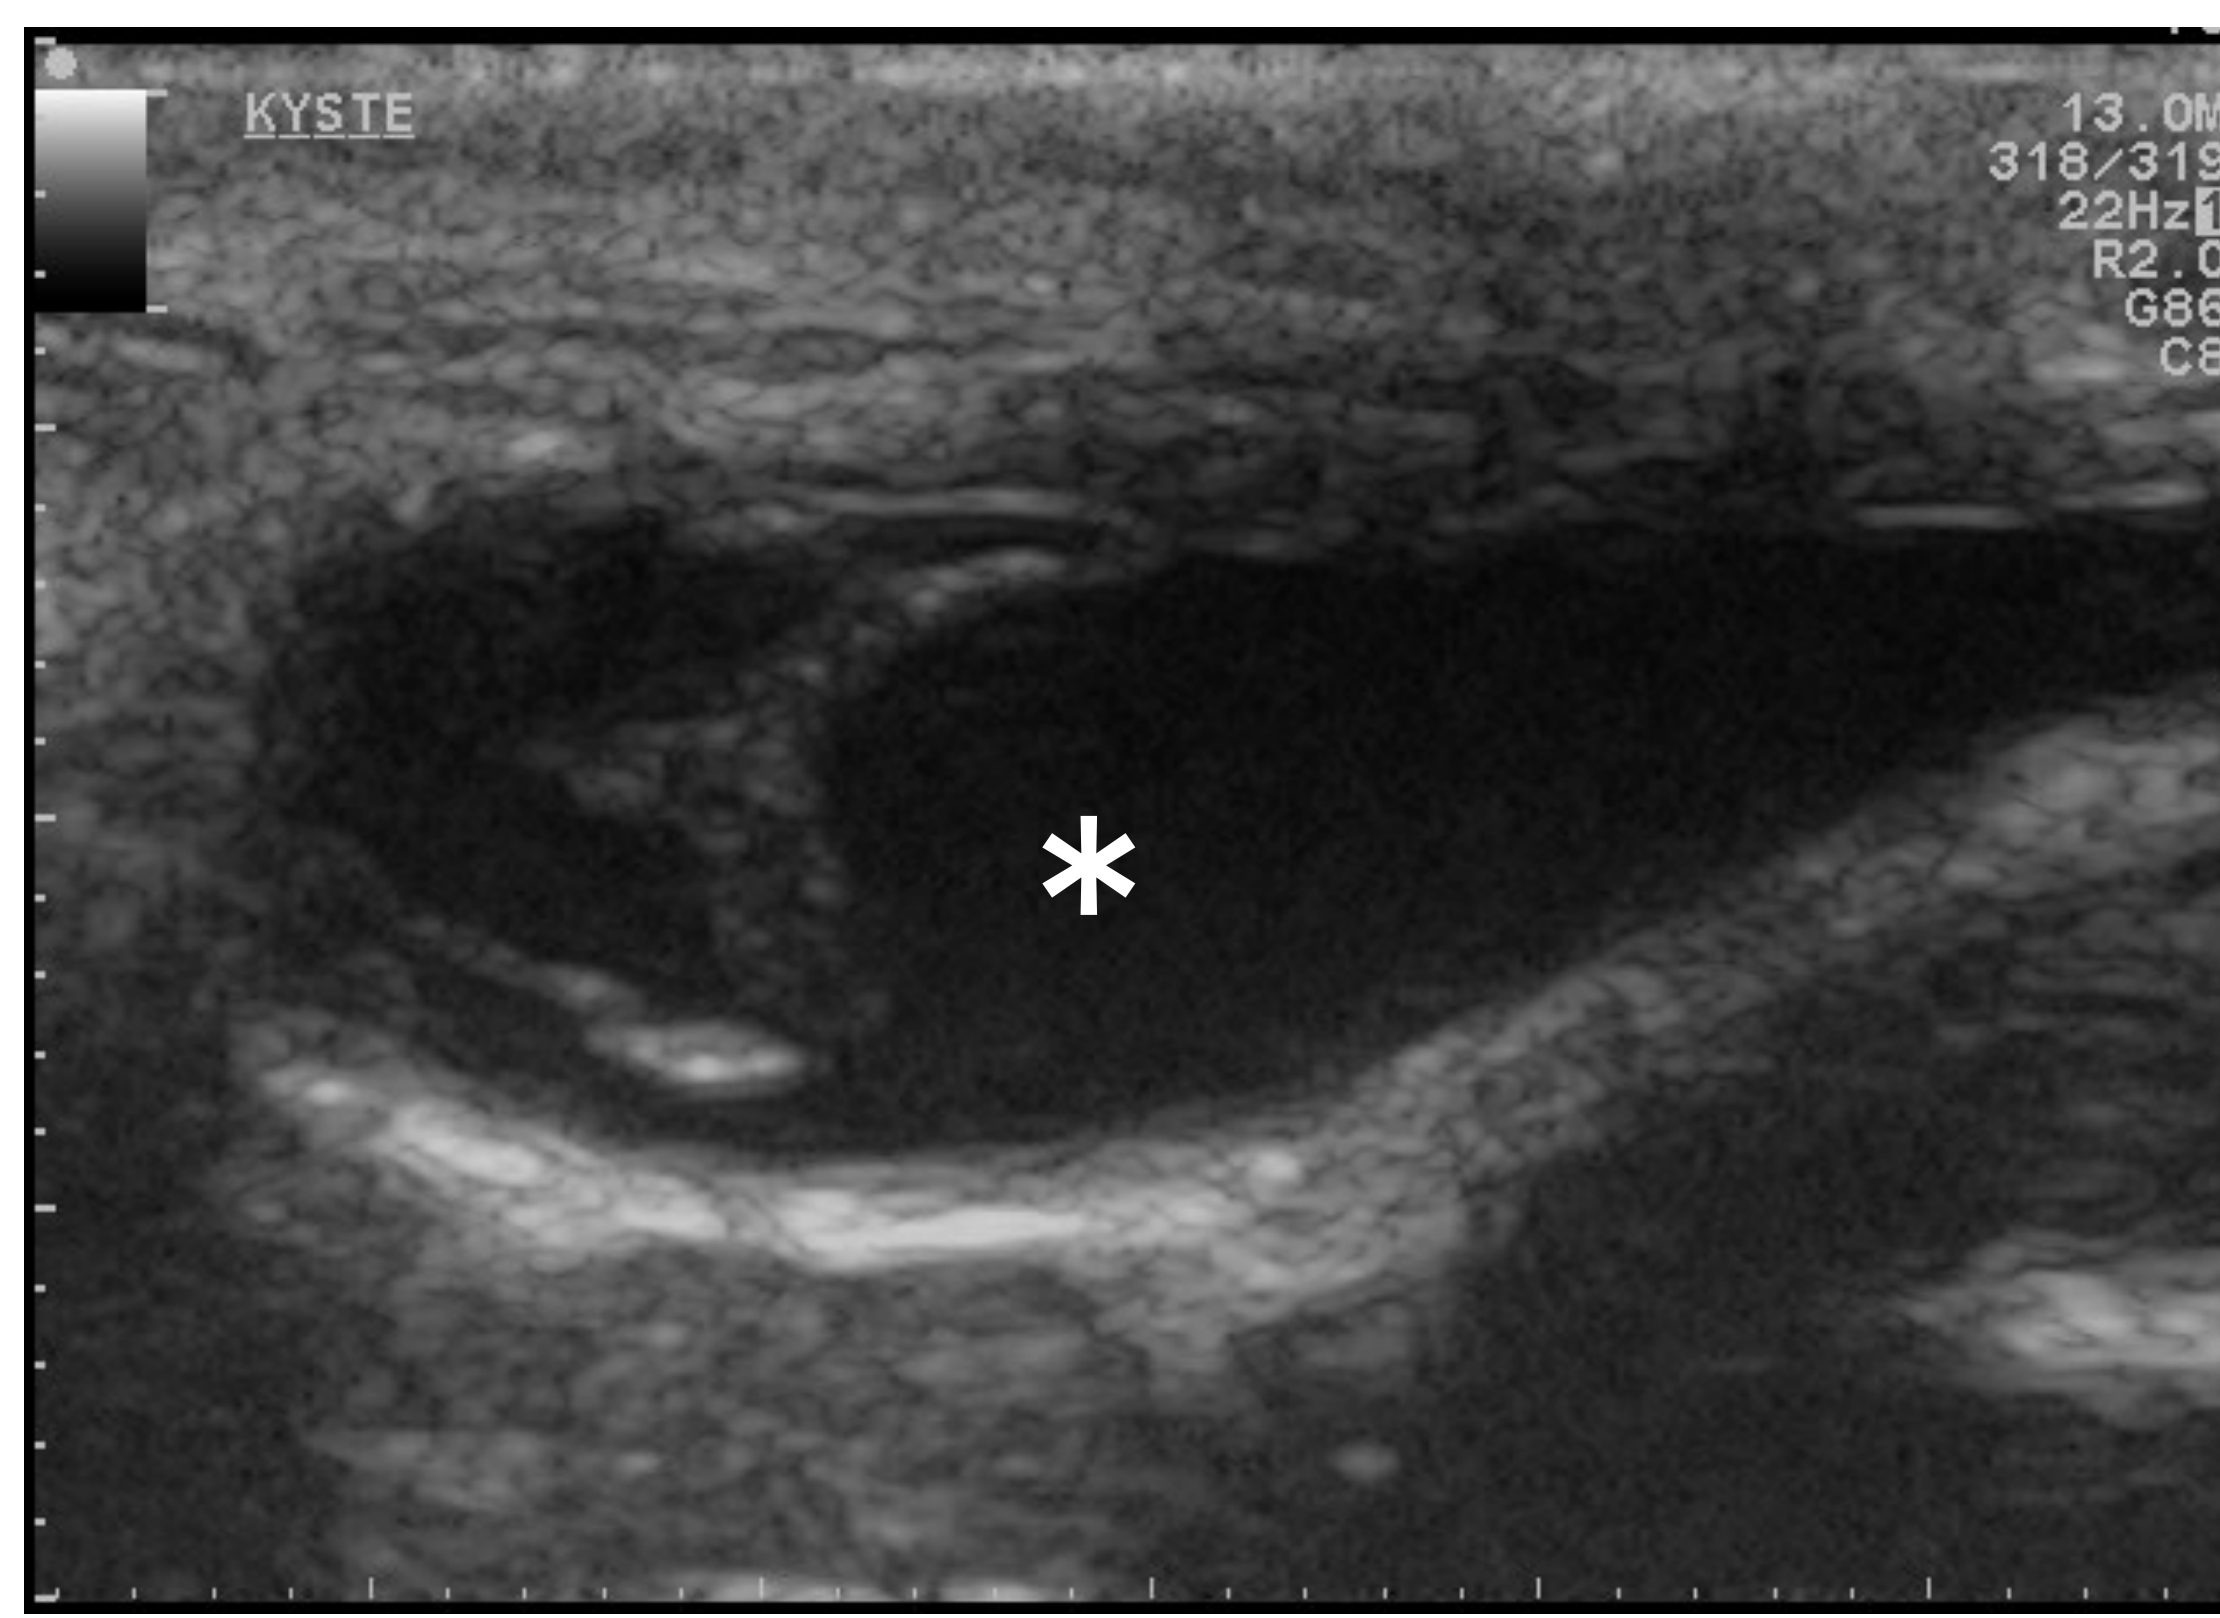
Longitudinal ultrasonographic image of the right parotid region. Anechoic fluid cavity with distal enhancement, delimited by an echoic wall is noted. This cavity is in continuity with an avascular anechoic tube, probably the parotid salivary duct. * : anechoic fluid cavity
